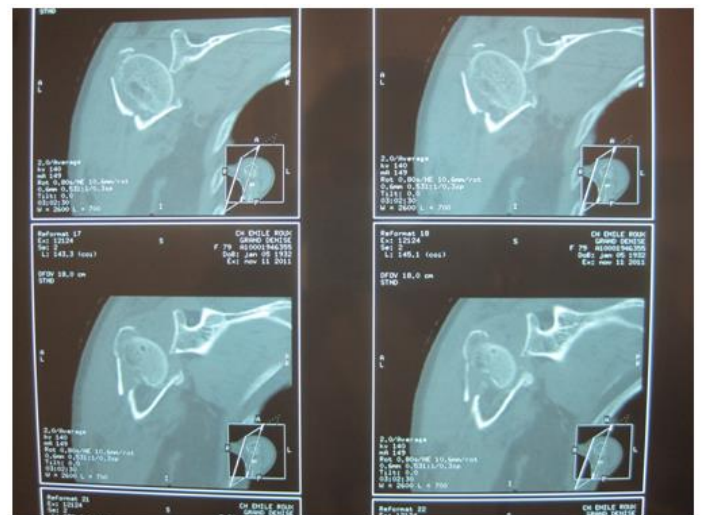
CT scan of the shoulder showing a lower anterior dislocation with complex fracture of the humeral head and fracture of the humeral shaft
